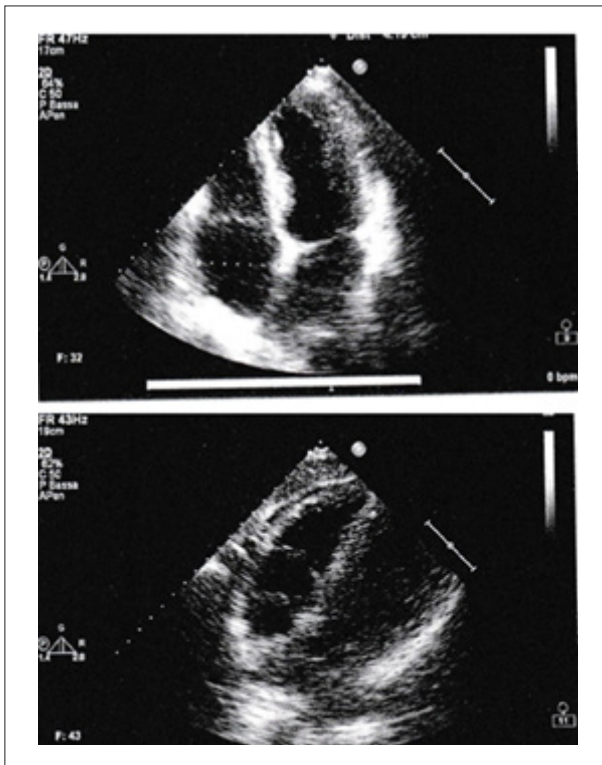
Echocardiogram at the admission: the interventricular septum thickness was normal and there was no evidence of right ventricular wall thickening.
